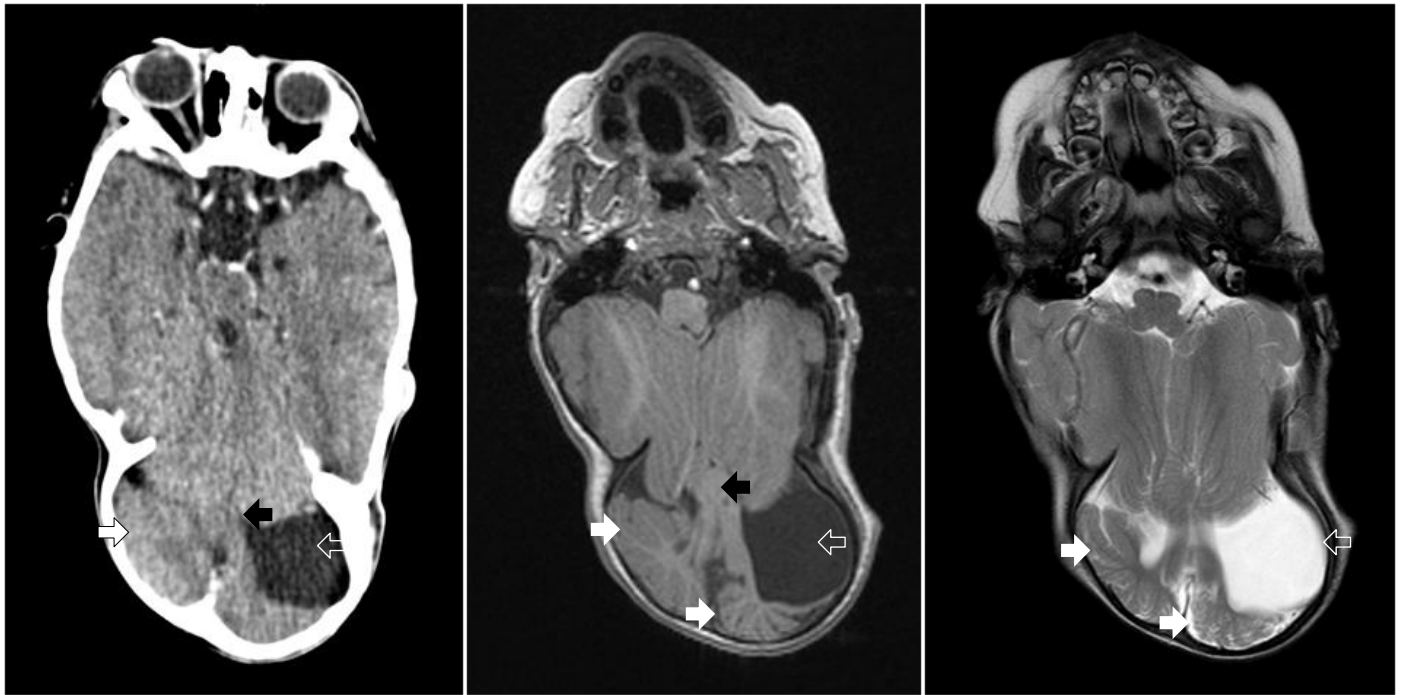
Axial CT (left), T1-weighted (middle) and T2-weighted (left) images showing a defect on the occipital bone and the parasite's dysmorphic cranium posterior to it. Cerebellar structures (white arrow), a rudimentary brainstem (black arrow), and a cystic extraaxial focus (open arrow) were seen within it.
